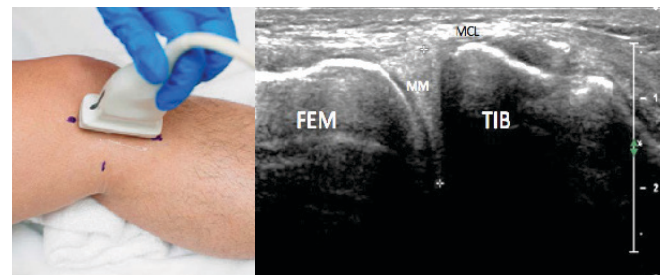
Probe position for short axis sonographic medial meniscus width measurements with corresponding sonographic image. Electronic calipers are seen in sonographic image placed at the outer and inner meniscal margins. FEM = femur; TIB = tibia; MM = medial meniscus; MCL = medial collateral ligament. Images courtesy of Jay Smith, MD, Mayo Clinic.
